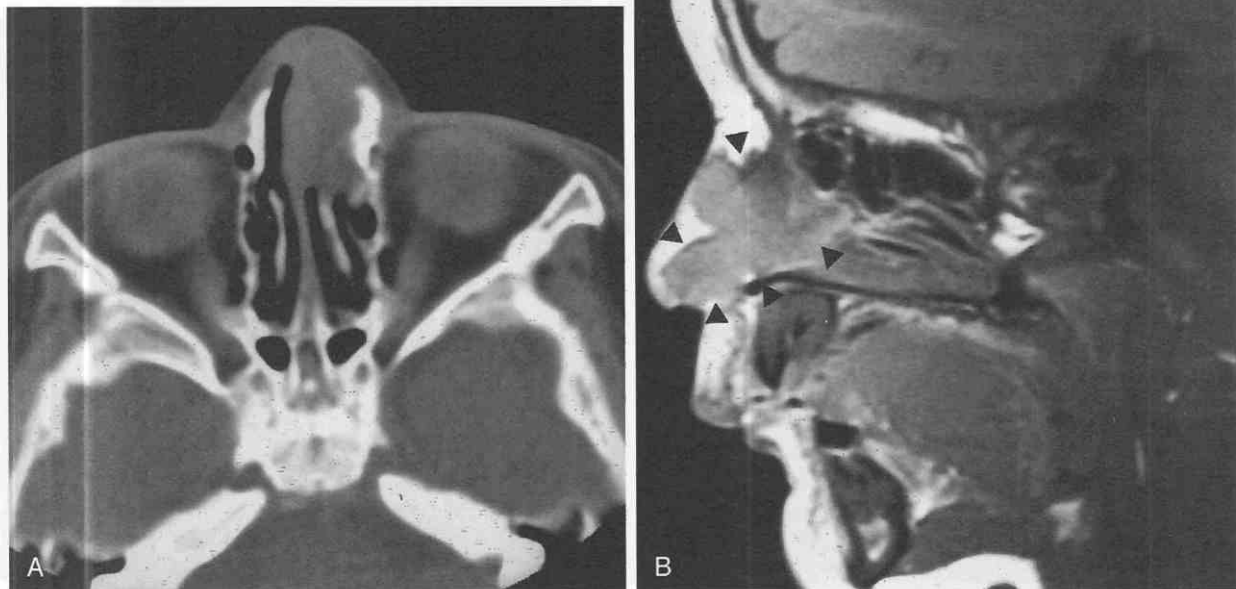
Nasal glioma. A, Axial noncontrast CT scan. The anterior nasal cavity on the left is filled with a mass of slightly less than soft tissue attenuation. There is bony remodeling of the nasal bone on the left. B, Sagittal T1-weighted MRI scan. The anterior nasal mass is isointense to gray matter (arrowheads) and shows no evidence of intracranial communication.
